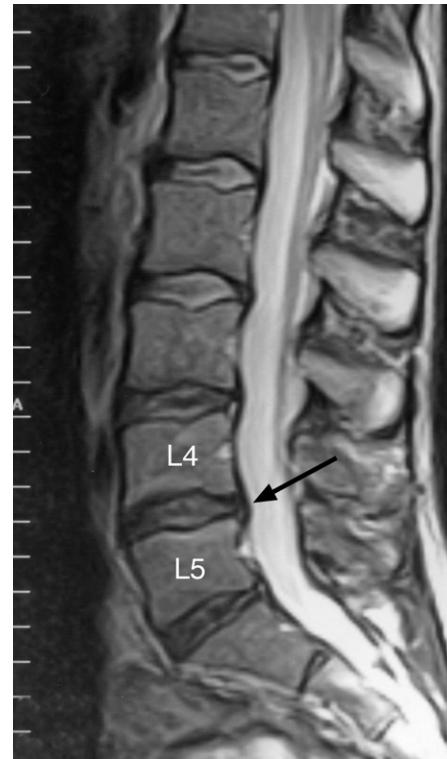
Lumbar spine MRI slightly left parasagittal T2-weighted image. Note the L4–5 level residual posterior annular bulge (arrow).
